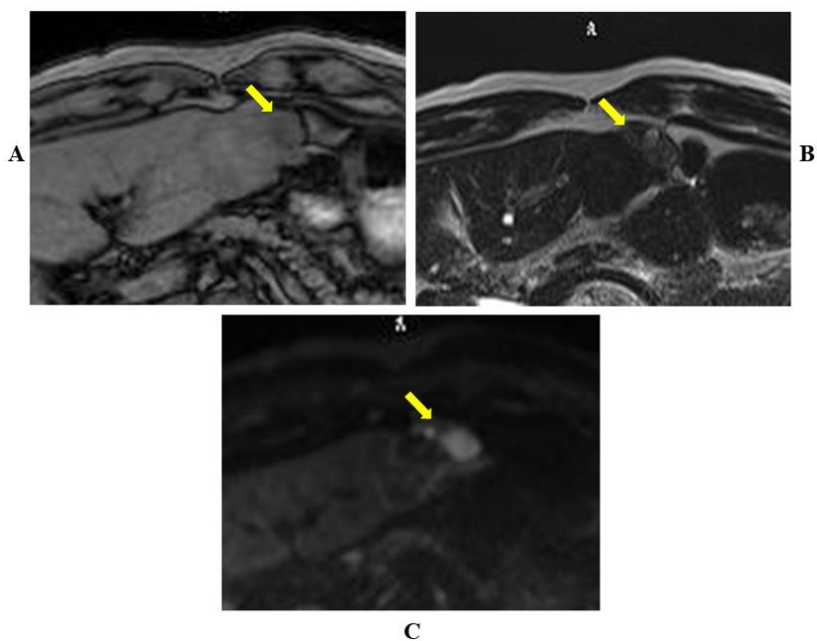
Magnetic resonance imaging (MRI) performed preoperatively. The central region of the tumor displayed elevated signal intensity on T1-weighted images and reduced signal intensity on T2-weighted images. The peripheral region displayed reduced signal intensity on T1-weighted images and elevated signal intensity on T2-weighted images, with reduced diffusion (arrow). A) T1-weighted image, B) T2-weighted image, and C) diffusion-weighted image.
